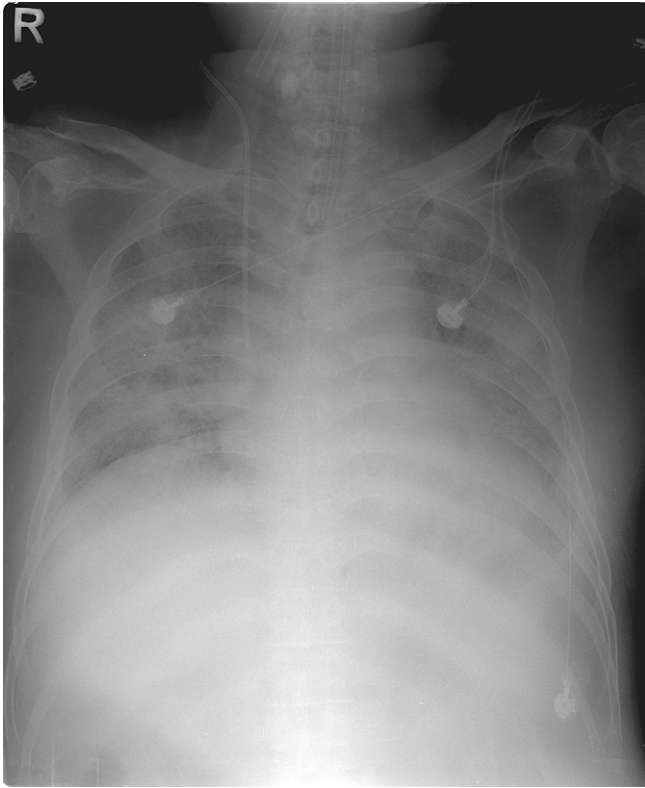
Chest radiograph showed bilateral pulmonary infiltrates, which was compatible with the diagnosis of acute respiratory distress syndrome.
